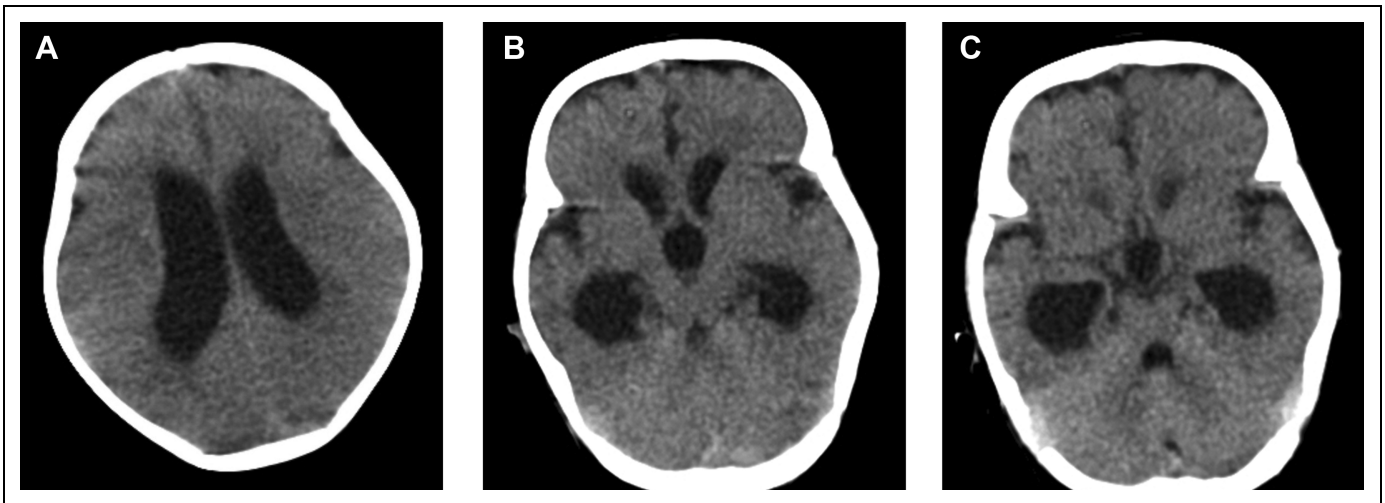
(A) Head computed tomographic (CT) scan showing hydrocephalus with dilated lateral ventricles. (B) Head CT scan showing dilated lateral and third ventricles. (C) Head CT scan showing dilated temporal horns of the lateral ventricles and small fourth ventricle.
